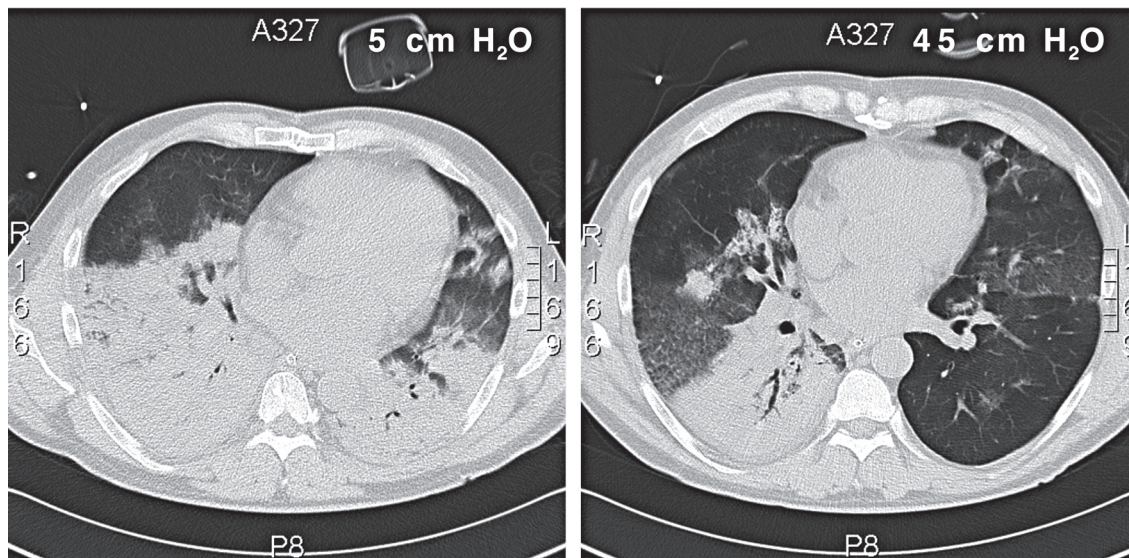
Potentially recruitable lung: chest CT images obtained during breath-holding sessions at consecutive airway pressures of 5 and 45 cmH<sub>2</sub>O, with the patient in the supine position. The percentage of potentially recruitable lung was defined as the proportion of lung tissue in which aeration is restored when increasing airway pressures from 5 to 45 cmH<sub>2</sub>O.<sup>13</sup> CT slices of the lung obtained 2 cm above the diaphragm dome at airway pressures of 5 cmH<sub>2</sub>O (left) and 45 cmH<sub>2</sub>O (right) from two patients with ARDS due to the novel influenza virus. The percentage of potentially recruitable lung was 35% in patient A (case 4), and 30% in patient B (case 16).
